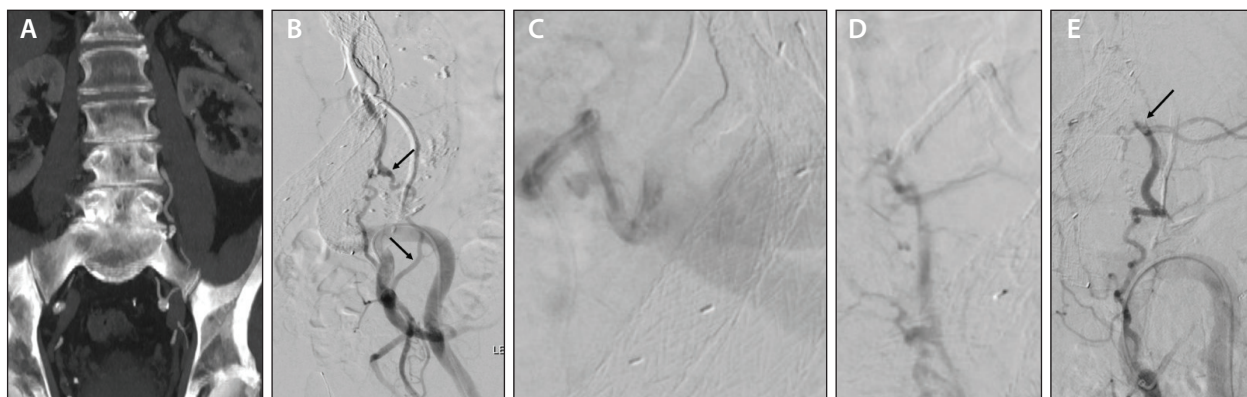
Preprocedure CTA demonstrating the left iliolumbar artery communicating with the L4 lumbar artery (A). Initial arteriogram demonstrating the same left iliolumbar branch communicating with the left L4 lumbar artery (arrows) (B). Selective oblique arteriogram demonstrating the L4 lumbar artery involving the endoleak (C). Postembolization oblique arteriogram with cessation of flow into the endoleak (D). Final anteroposterior arteriogram with cessation of flow in the ascending iliolumbar branch after postembolization (arrow) (E).
